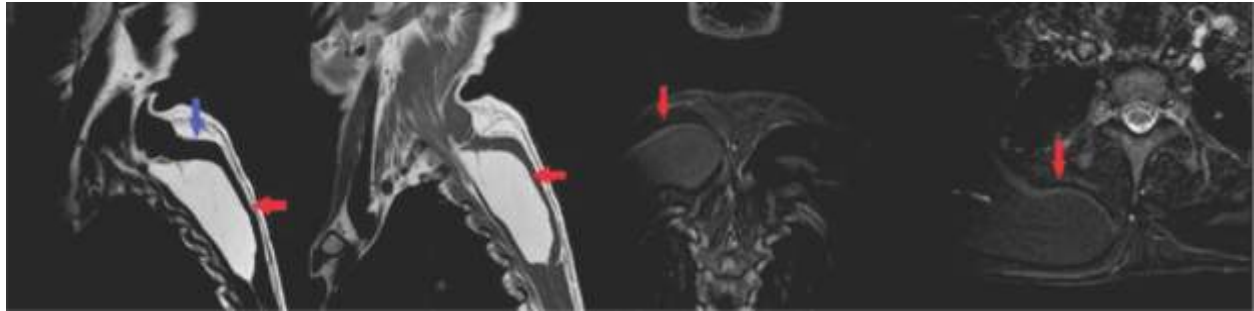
MRI T2WI & T1WI Sagittal showing Well Defined Lobulated Mass Appearing Hyperintense (Red Arrow) in Intermuscular Plane of Trapezius (Blue Arrow) and Rhomboid Major in the Right Upper Back. PD Fat Saturation Coronal & Axial STIR Image where Lesion Appears Hypointense (Red Arrow)
